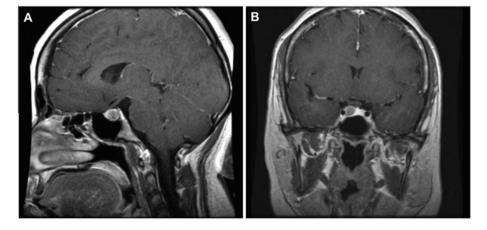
Post-gadolinium T1-weighted MRI (A: sagittal; B: coronal) of a 22-year-old woman with a microprolactinoma on the right side of the sella, who presented with amenorrhea and galactorrhea. Her serum prolactin was 89 ng/mL.
